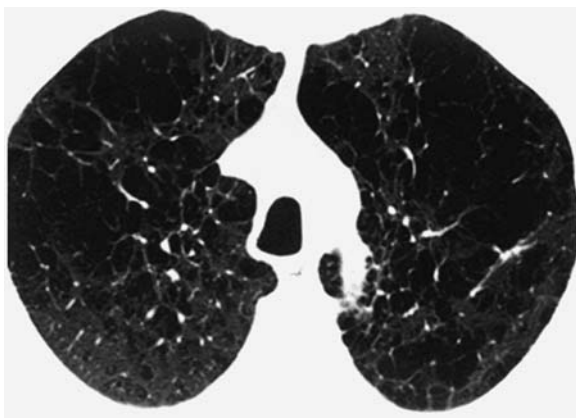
Centrilobular emphysema on thin-section computed tomography. There is characteristic symmetrical and “permeative” lung destruction
